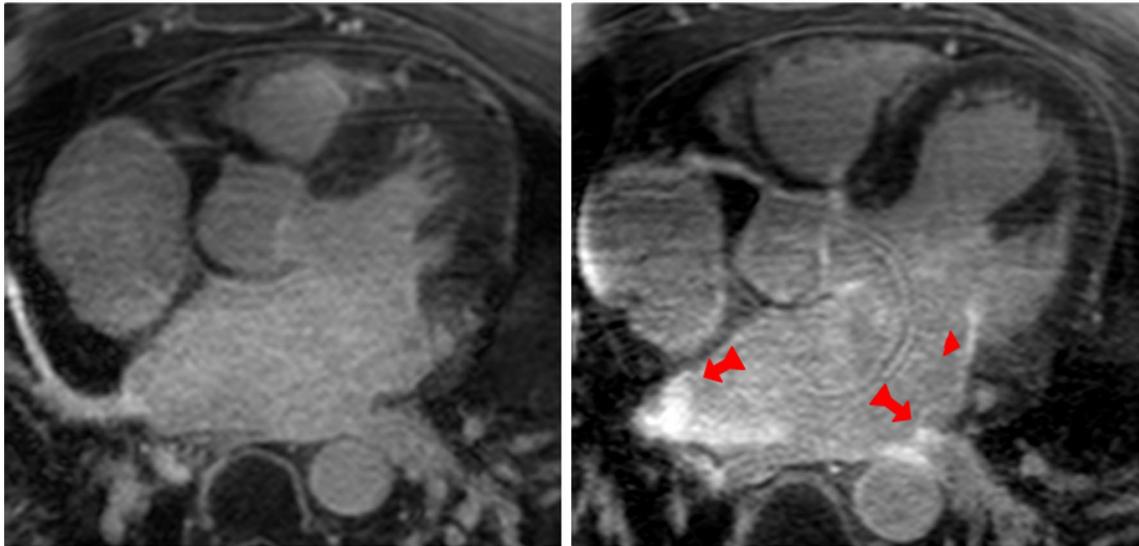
Pre- and post-ablation cardiac MRI with gadolinium late enhancement in the follow-up examination at the pulmonary vein ostia (arrows) and along the anterior mitral line (arrowhead) in terms of scarring along the ablation pathways
